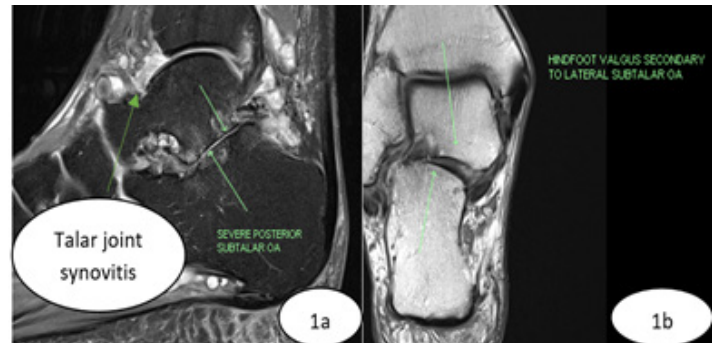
a) and b): MRI of the right ankle shows severe Subtalar OA, talar synovitis, and hindfoot valgus.
